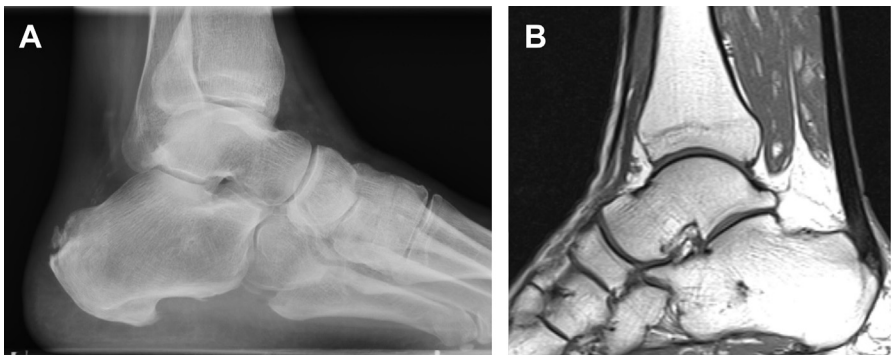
Radiographs (A) and MRI (B) of a patient with insertional Achilles tendinopathy showing bone spurs and intratendinous calcifications at the bone insertion.
